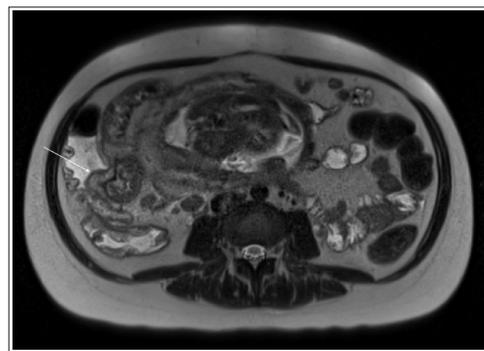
MR Abdomen performed using the Standard MRI pregnancy appendix protocol without Gadolinium. The arrow indicates an area of moderate circumferential cecal wall thickening measuring up to 0.7 cm involving 7 cm length of cecum. There is adjacent inflammation of the terminal ileum for an 8 cm segment with moderate bowel wall thickening measuring 0.6 cm.
